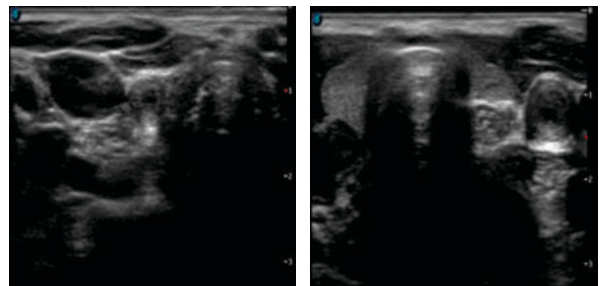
CASE 1: Axial view of the ultrasound of both common carotid arteries showing a circumferential increase in wall thickness that appears moderately echogenic, with luminal narrowing.
